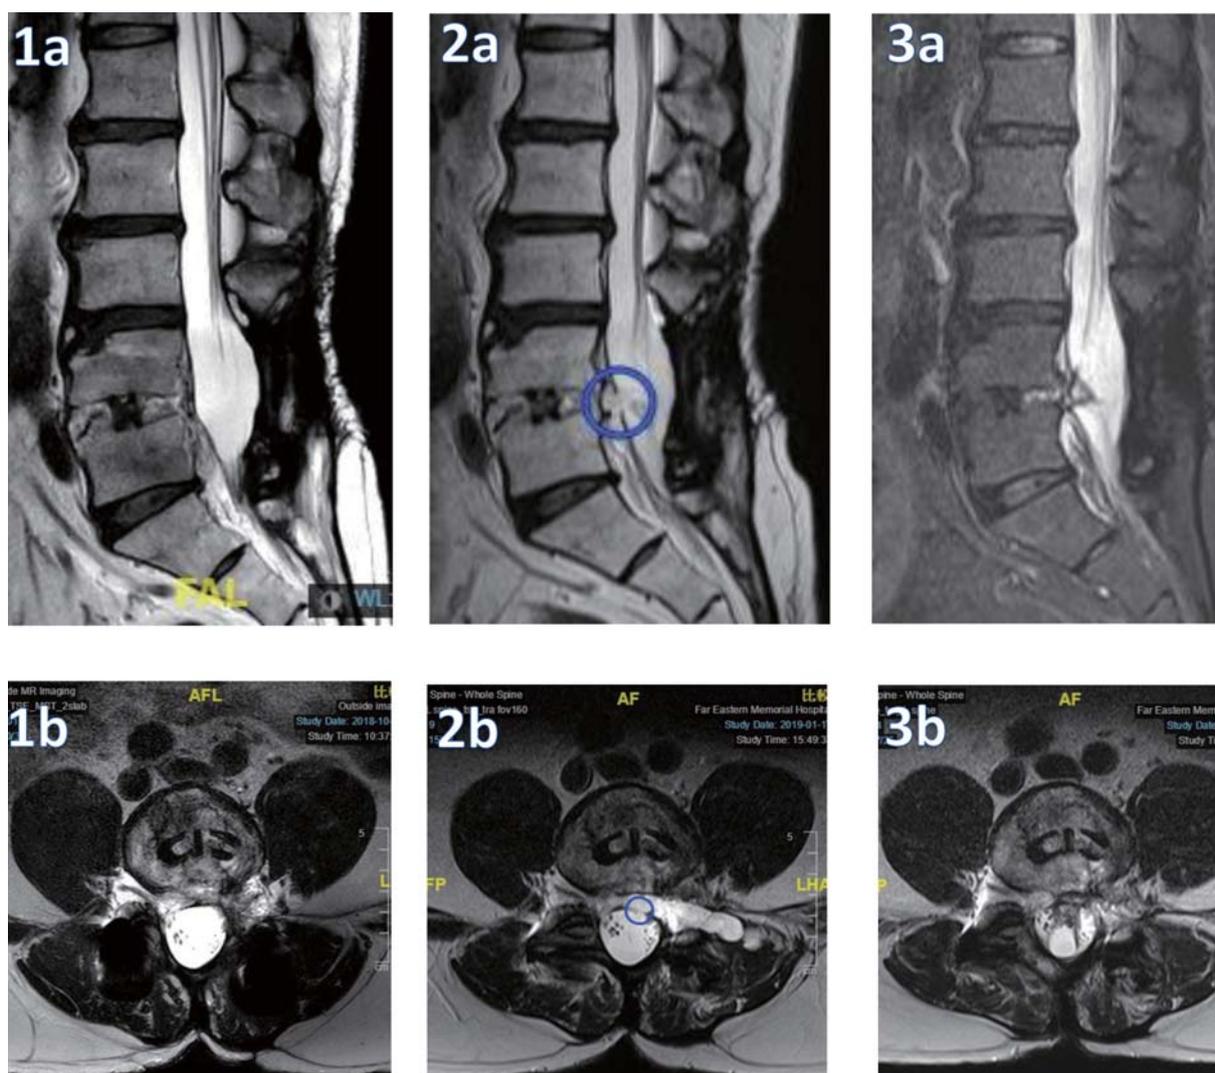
Baseline T2-weighted magnetic resonance image of the longitudinal view of the lumbar spine showing evidence of post-laminectomy with transpedicular screw placement and diskectomy with intervertebral cage placement in L4-L5.
